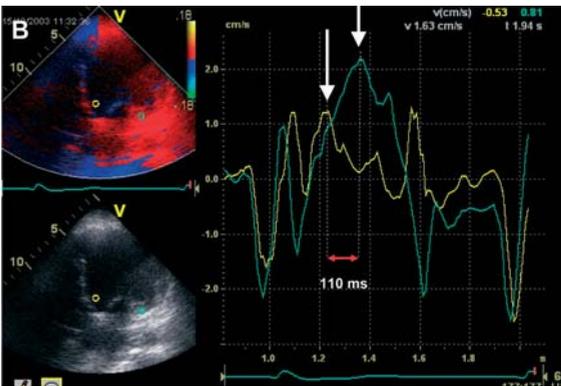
Color-coded tissue Doppler imaging
